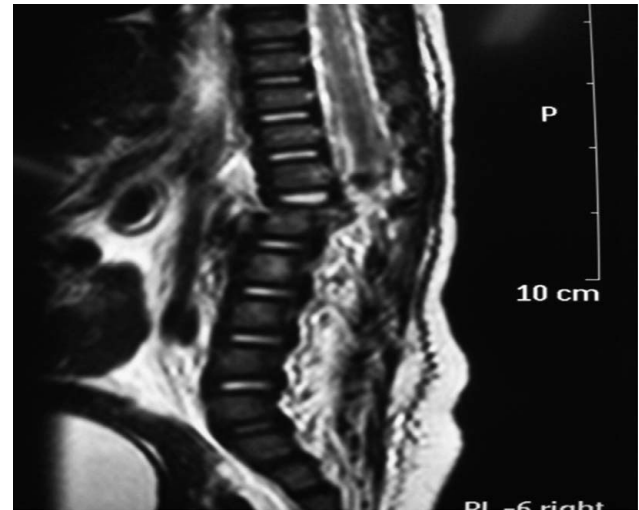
Thoracolumbar MRI shows Chance fracture at the T12–L1 levels.
